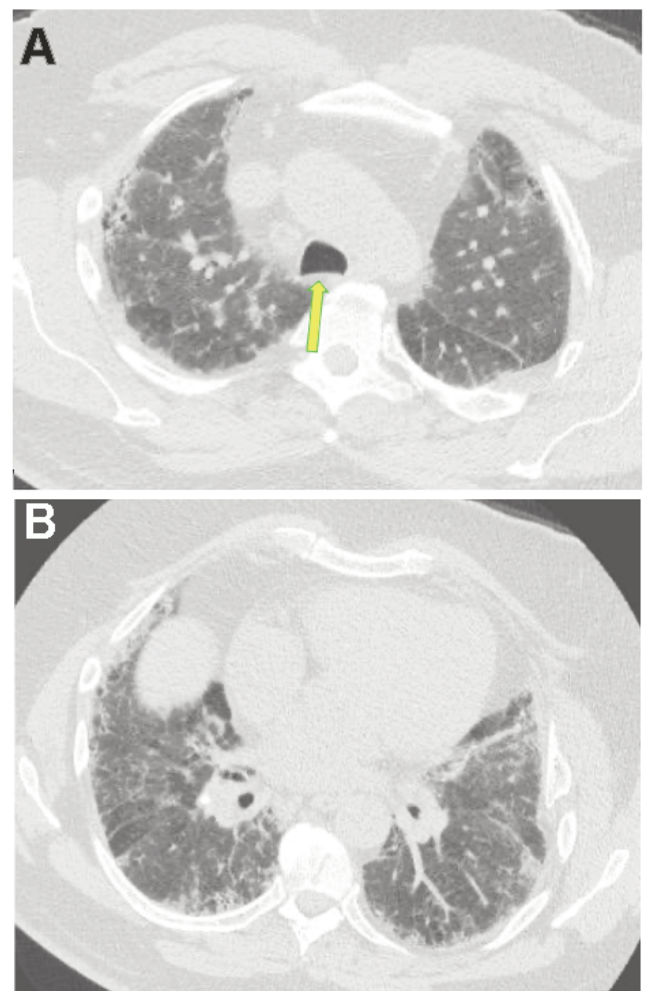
Expiratory HRCT images at presentation from a patient with RA-ILD at the level of the aortic arch (A) and left inferior pulmonary vein ostium (B). Images demonstrate a normal homogenous increase in lung attenuation with expiration and no significant air trapping. Significant air trapping (diffuse in three or more lobes) would suggest an alternative diagnosis such as fibrotic hypersensitivity pneumonitis. Note the flattening of the membranous trachea (arrow) suggesting adequate expiratory effort. If the trachea maintains a rounded configuration on both the inspiratory and expiratory scans, this suggests the expiratory effort was poor, which limits the ability to assess for air trapping.
